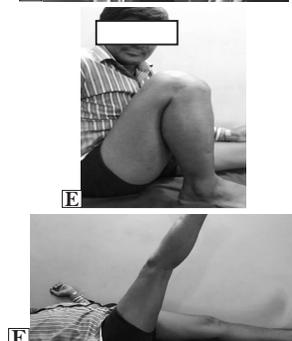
32 year old male patient with schatzker type VI fracture treated with dual plates. (A) Pre op X-ray (B) Posr OP X-Ray (C) 4 week follow up (D) 13thh week follow up X-Ray (E,F) Clinical Images
